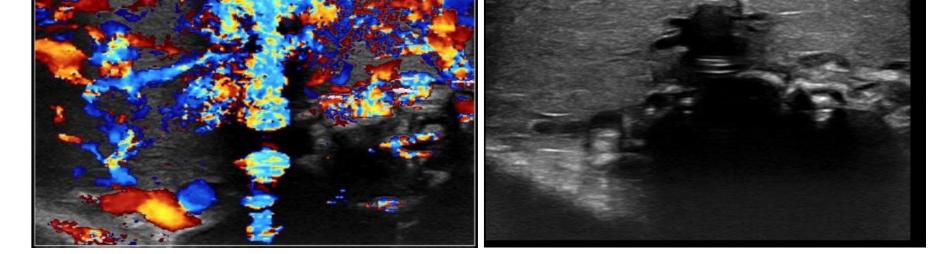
Thyroid gland as visualized on post-natal ultrasound and with doppler
